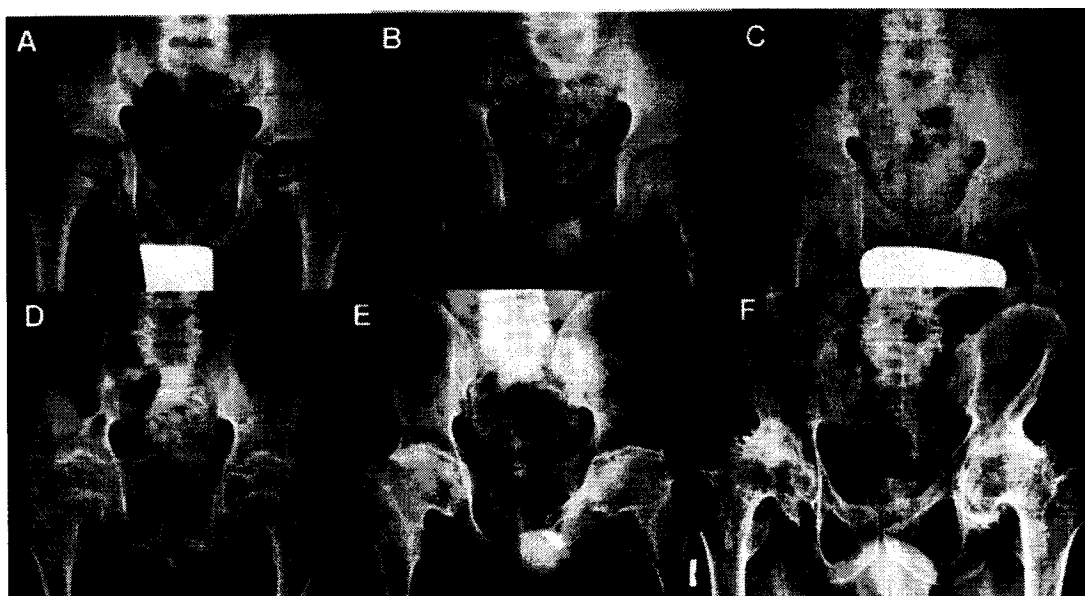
Bone changes in pelvis x-rays in several PPRD patients: at 5 years (A), the pelvis appears fairly normal; at later ages (B = 6 years, C = 10 years, D = 12 years) there is reduction of the articular space indicating progressive loss of articular cartilage correlating with progressive hip stiffness and pain. Epiphyses are rather large and become progressively flattened. In adults (E = 21 years; F = 45 years) there is marked cartilage loss in the interarticular space and osteopenia. The external profile of the acetabula is characteristic, with a distinct "lip" overriding the femoral neck. D and E are from the same patient at age 12 and 21, respectively.
